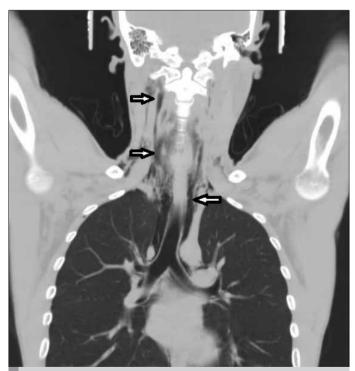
Computed tomography scan reveals subcutaneous emphysema (arrows)
